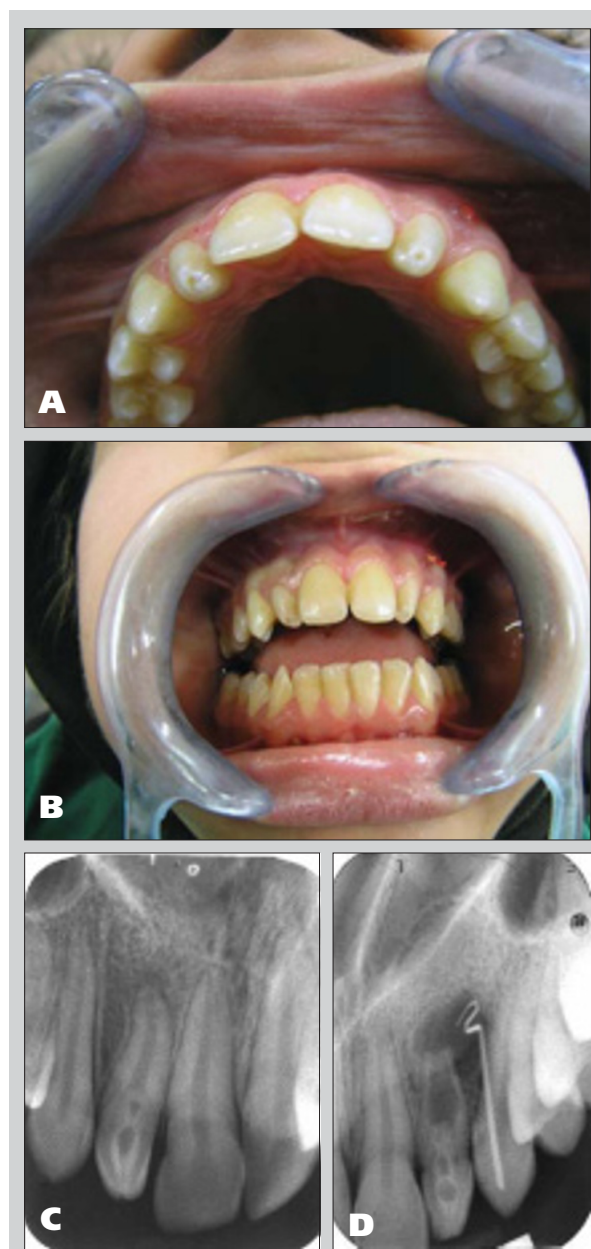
Case 1. Clinical (A and B) and radiographic (C and D) appearance of the invaginated right (C) and left (D) maxillary lateral incisors, showing the sinus tract on the left lateral incisor and peg-shaped crowns for both.
